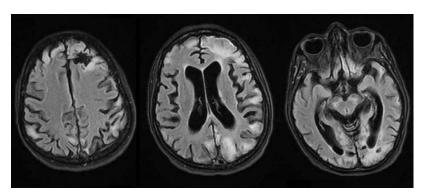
Follow-up brain MRI study showed significant brain atrophy.
